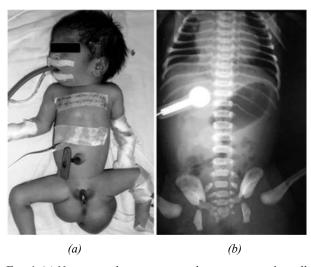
(a) Neonate with sacrococcygeal teratoma type 1,small perineum and vestibular fistula, with red rubber catheter not going beyond 10 cms into the esophagus; (b) radiograph showing dilated stomach shadow, soft tissue shadow in the sacrococcygeal region, normal vertebrae and increased cardiothoracic ratio.
